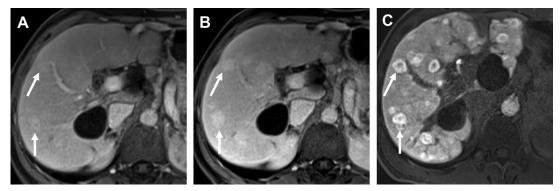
A 51-year-old woman with history of autoimmune hepatitis. Axial portal venous phase MR imaging (*A*) shows indistinct hepatic lesions (*arrows*). The lesions became more conspicuous during the transitional phase (*B*). All lesions demonstrated intense retention of contrast and central scar during the hepatobiliary phase and central scar (*C*), compatible with FNH-like nodules.
